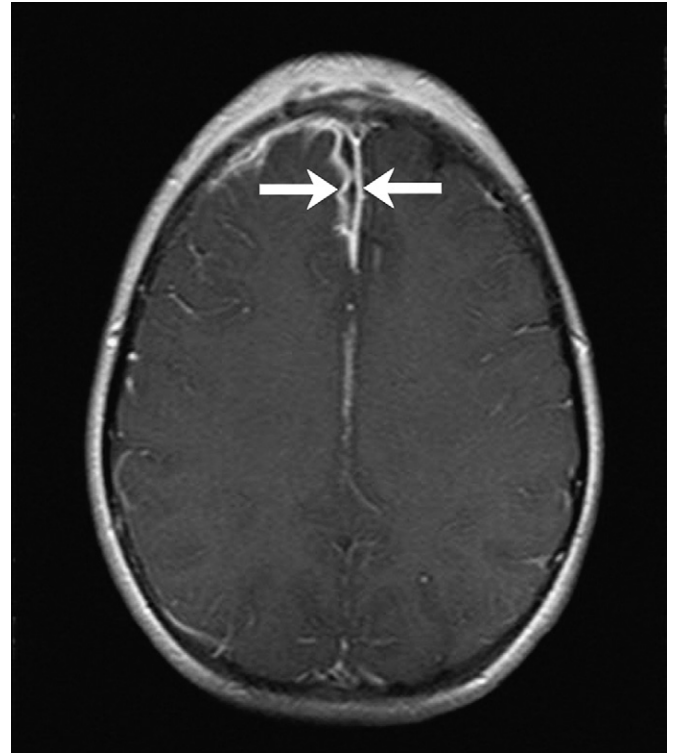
Subdural abscess or subdural empyema. Axial T1-weighted MRI with gadolinium demonstrates a small rim-enhancing right frontal paramedian subdural abscess (*arrows*). This area was restricted on DWI (not shown).
